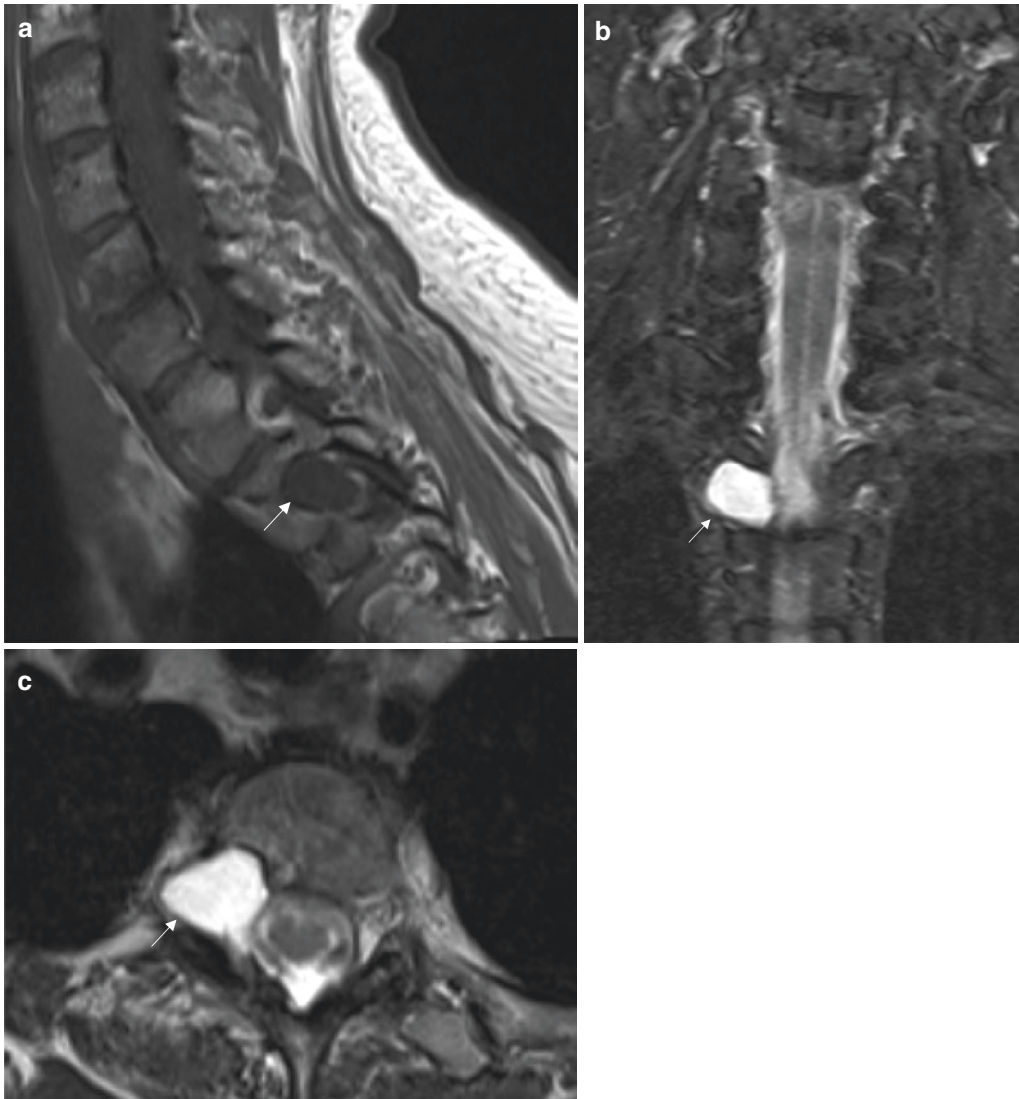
(a) Sagittal T1-weighted image demonstrates a dark lesion in the right T2-T3 neural foramen along the nerve root (white arrow). (b) Coronal STIR and (c) axial T2-weighted images demonstrate that this represents a
